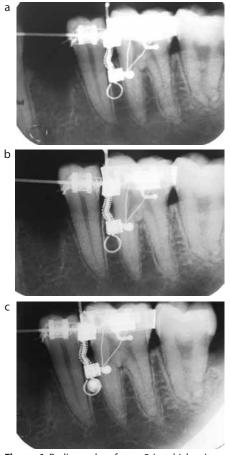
Radiographs of case 2 in which microimplant is placed between LL5 and LL6: (a) site selection between LL5 and LL6; (b) VRSG adjusted by loosening ligature; (c) micro-implant in position with VRSG.
